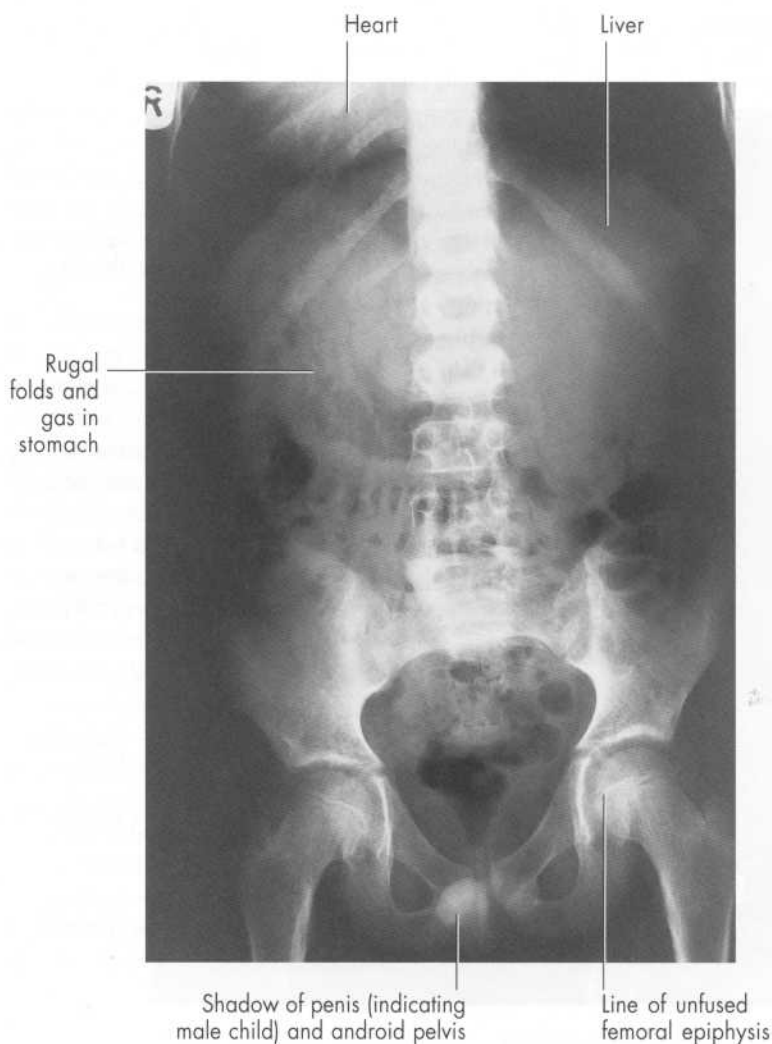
Supine AP radiograph of a child with left-sided abdominal pain.
